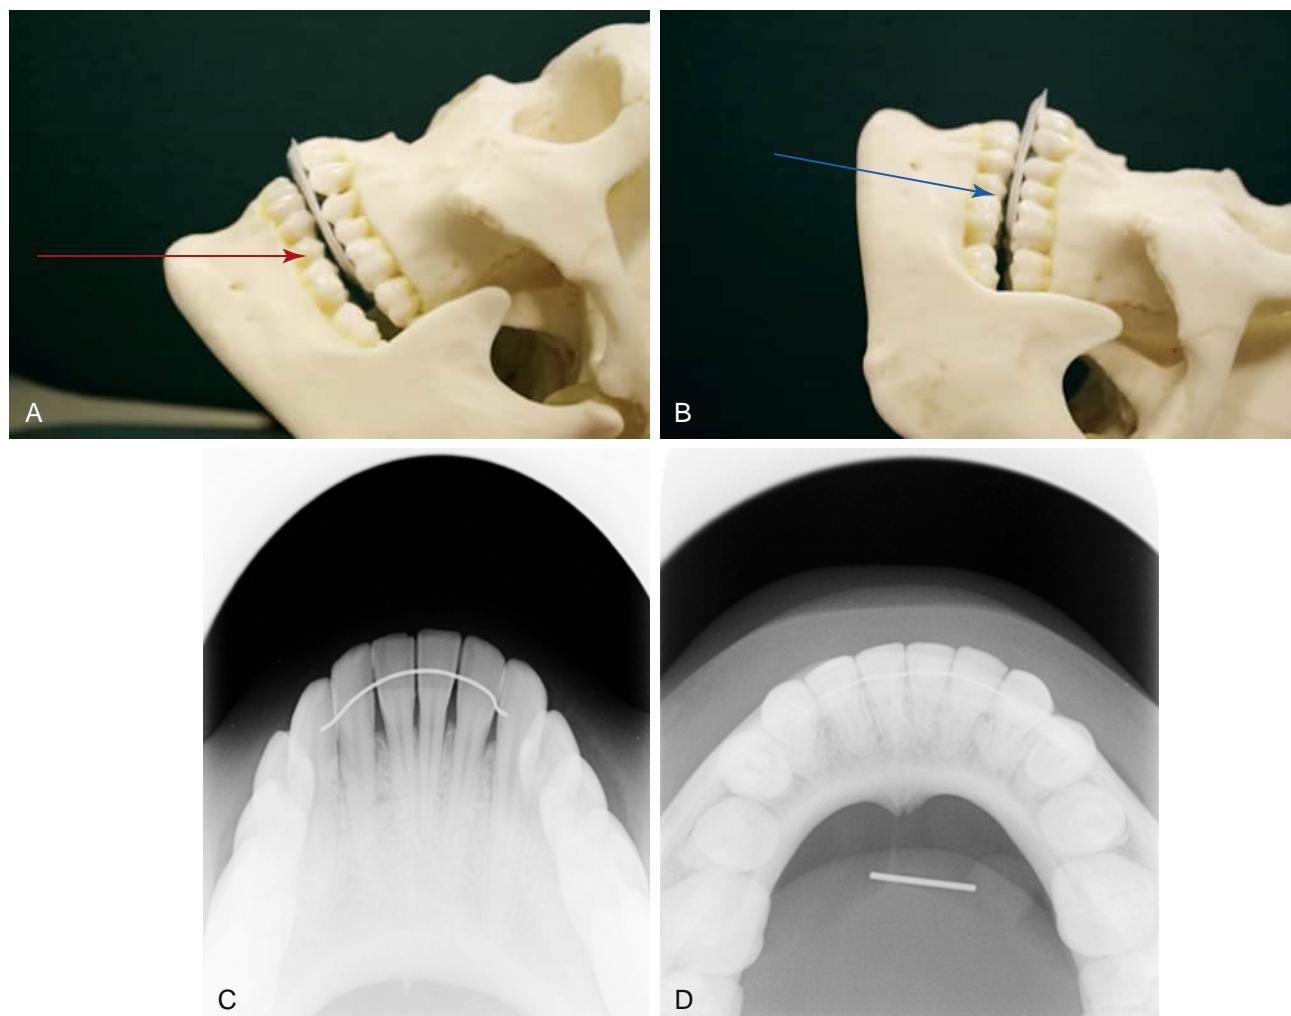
(A) The position of the x-ray source (red arrow) 45 degrees occlusal to the mandible. (C) An example of this projection. (B) The position of the x-ray source (blue arrow) 90 degrees occlusal to the mandible. (D) An example of this projection (patient with a small piece of a metal rod in the floor of the mouth).
